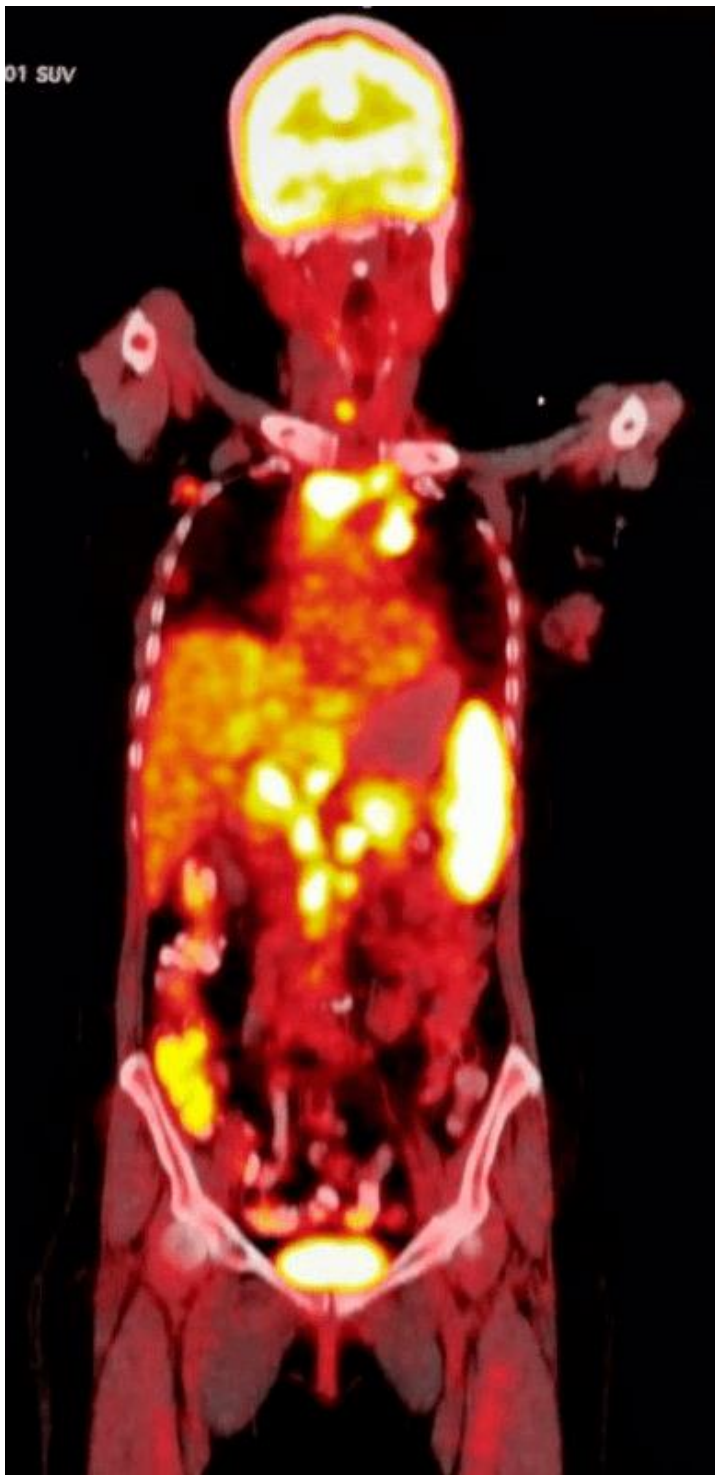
18-FDG PET demonstrating hypermetabolic right axillary nodes, right internal mammary node, mediastinal/hilar, upper abdominal lymphadenopathy along with diffuse splenic hypermetabolism
